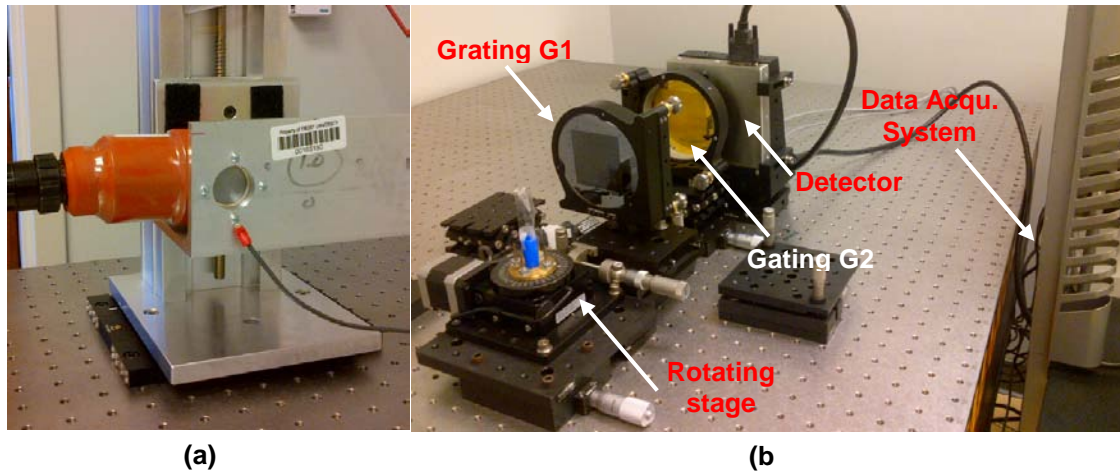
A picture showing the prototype x-ray phase CT system: (a) the micro focus x-ray tube and (b) the rest of the system.
